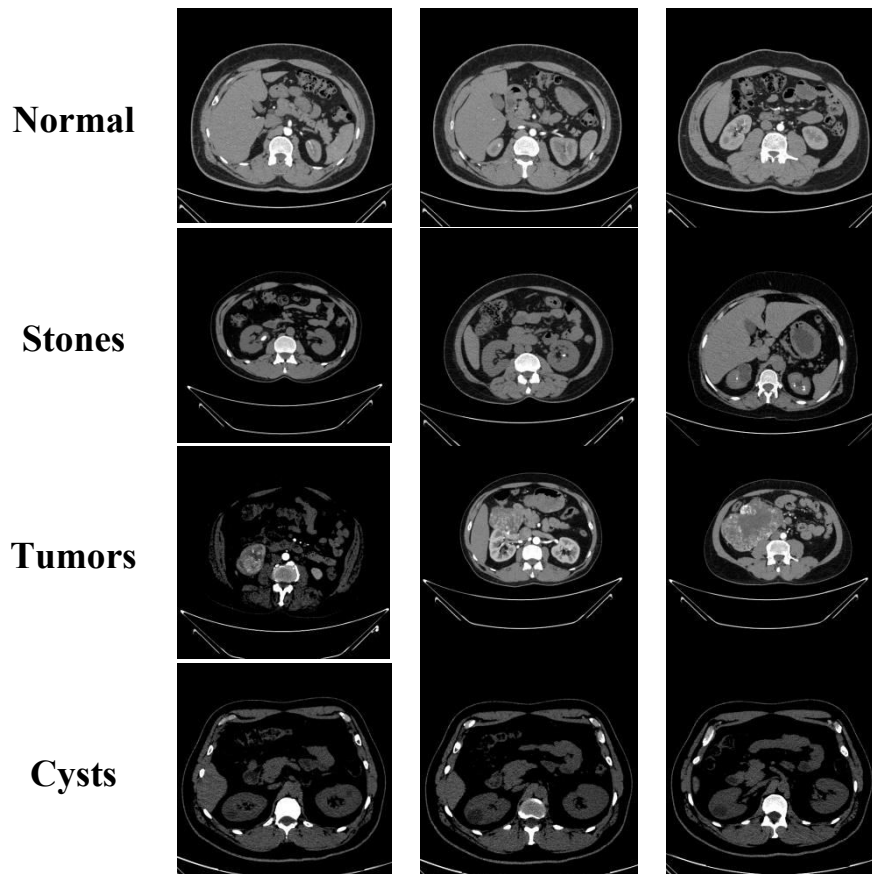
SampleCT-Scans Showing Tumors in Kidneyfrom CT-KIDNEYDataset
